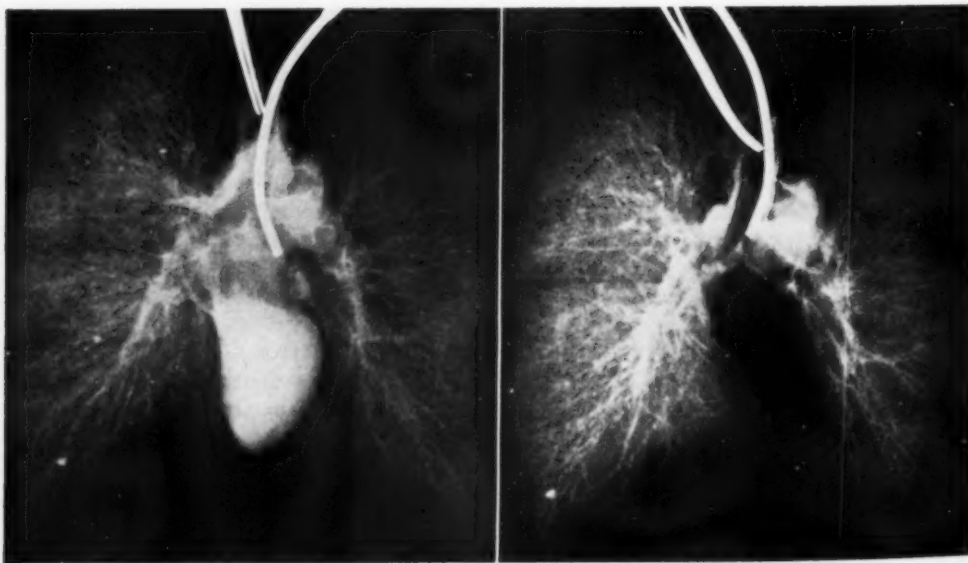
A. Postero-anterior roentgenogram of the excised re-inflated lungs of the patient shown in Fig. 2. The heart and aorta are intact, and the tumor is visible in the lung above the left hilar structures. B. The heart and aorta have been removed, allowing one to see the tumor to better advantage. A small metastatic lymph node previously unsuspected is now visible above the right main stem bronchus at its origin.
